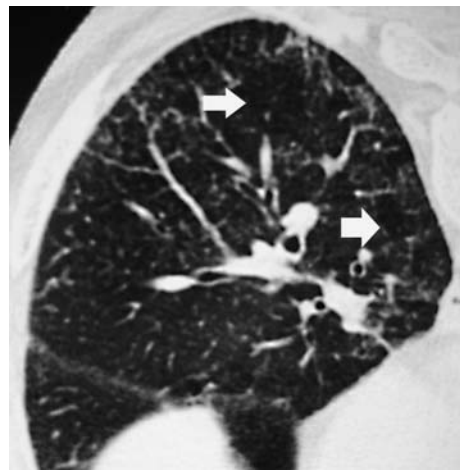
Prone inspiratory thin-section computed tomography of an asbestos miner showing areas of differing attenuation with regions of pulmonary parenchyma which appear blacker than adjacent areas (*arrows*), an indirect sign of small airways disease. The difference may be accentuated on end-expiratory sections (not shown)
